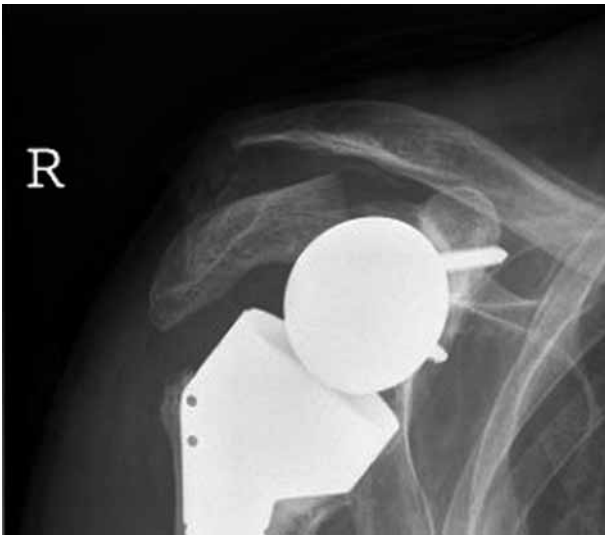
Standard radiographs of the right shoulder demonstrating the displaced scapular spine fracture. No loosening or damage to any of the Delta III components is noted.
